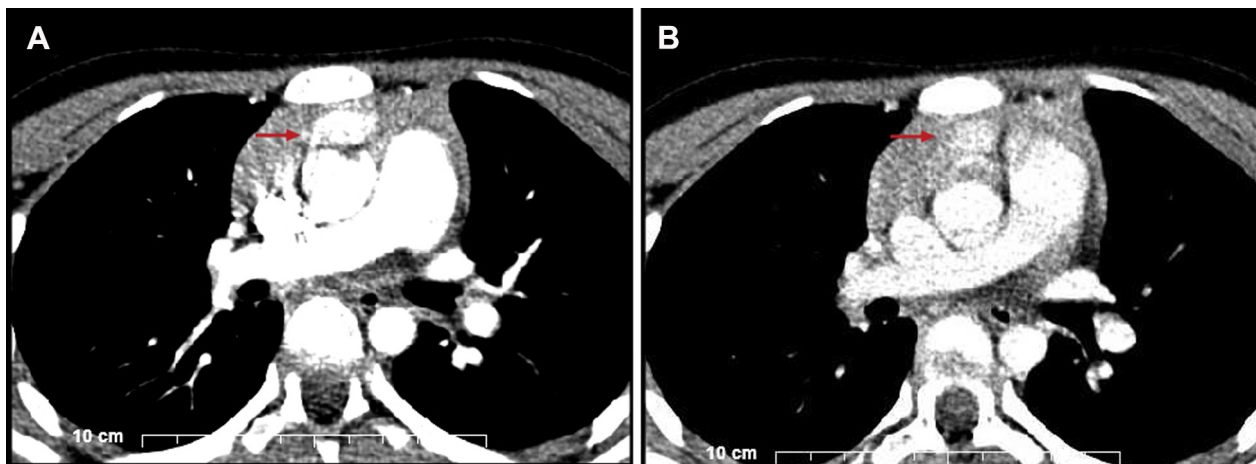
Axial views of chest 4-dimensional CT demonstrating the ectopic parathyroid adenoma (arrow). A, Arterial phase. B, Delayed phase. CT = computed tomography.
